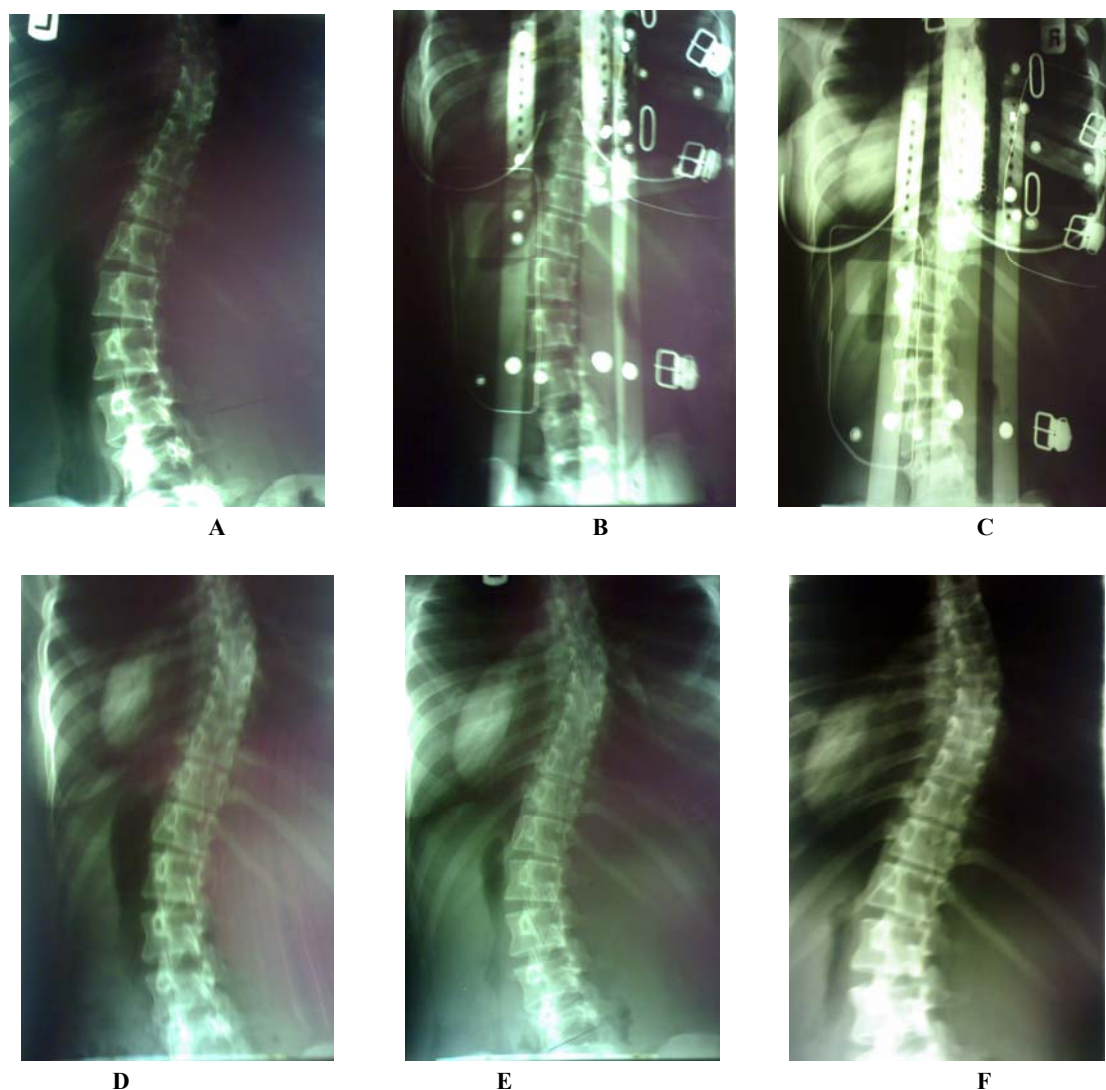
Radiographs of a 13 year-old female with 4 year full-time and 1 year part-time in brace. (A) Anteroposterior prebrace spinal radiograph with right main thoracic (T4-T10) of 40° and left lumbar (T11-L3) of 40°. (B) Radiograph, one year after Milwaukee brace with metal wire around thoracic and lumbar pads, MT in brace was, 30° and L, 24°. (C) Radiograph at 4 year in brace, MT was 34° and L, 30°. (D) At stop stage, out of brace, MT, 40° and L, 44°. (E) 1 year after stop of brace with MT, 40° and L, 45°. (F) 2 year after stop of brace, MT decreased to 30° and L to 32°.
